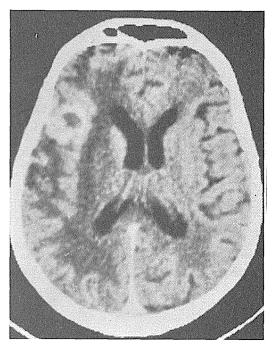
Brain CT in February 1992.
